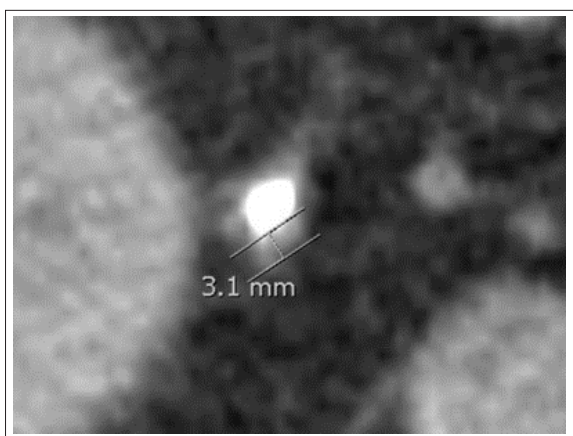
Ureteral wall thickness measured on non-contrast computed tomography scan.
